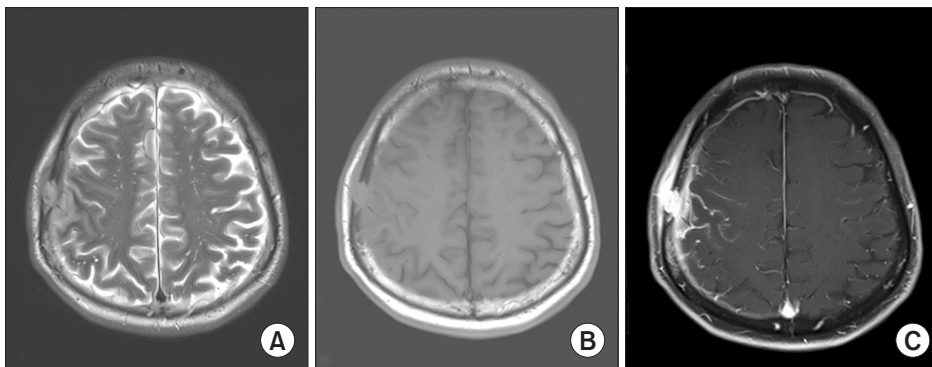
Brain magnetic resonance imaging of preoperation shows an enhanced extraaxial mass-like lesion with adjacent subgaleal tissue thickening/enhancement, bony destruction in the right frontal area, dural thickening/enhancement, and leptomeningeal enhancement along the right cerebral convexity. (A) T2-axial, (B) precontrast T1-axial, and (C) postcontrast T1-axial images.
